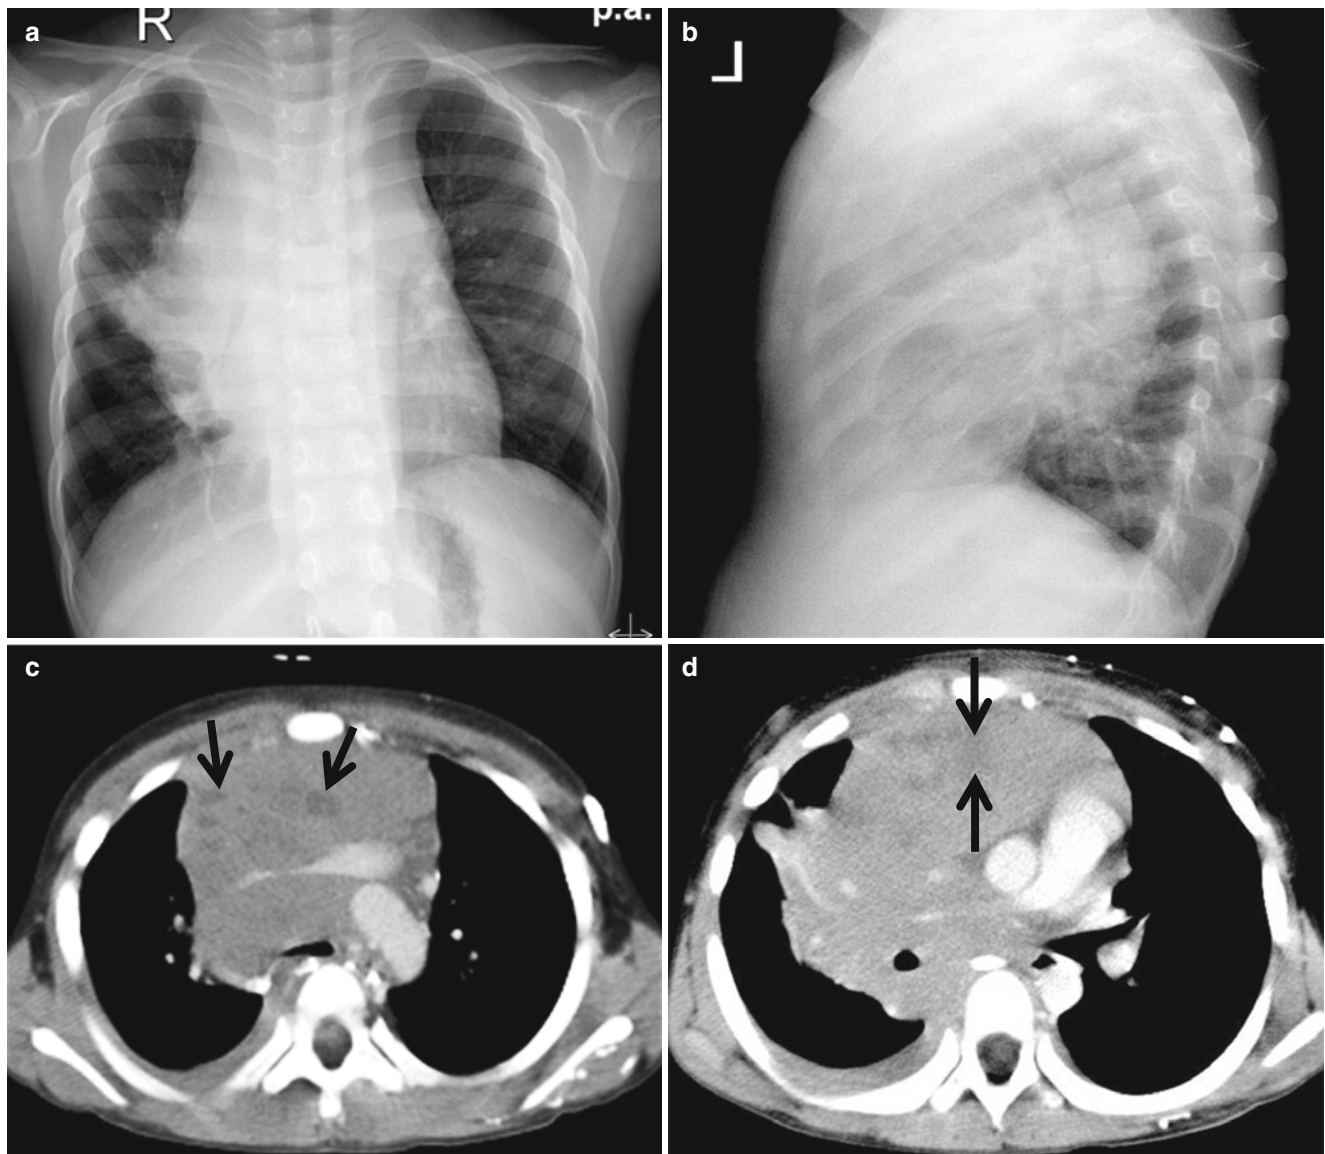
Non-Hodgkin's lymphoma in a 7-year-old boy with dyspnea. (a) Frontal chest radiograph shows mediastinal widening. (b) Lateral chest radiograph shows that the mass is located in the anterior and middle mediastinum. (c, d) Contrast-enhanced CT shows a
